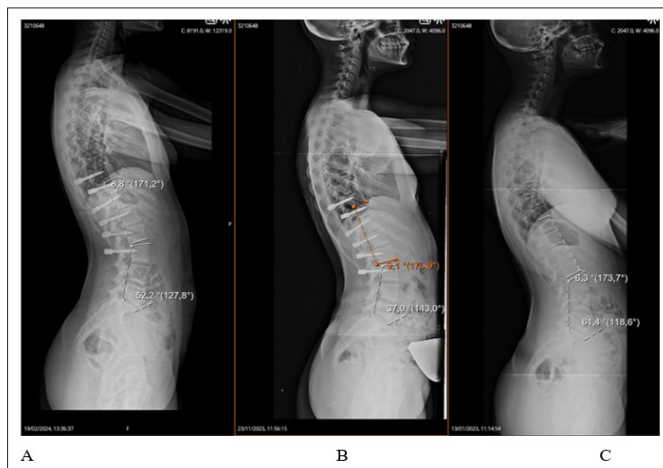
Lateral radiographs : A. 1y FU, B. 8months FU, C. pre-op Regarding lumbar spinal range of motion (ROM) 1y post-operatively, it is definitely preserved but reduced to approximately 50%, when compared to pre-op figures, based on clinical grounds (figure 5).
